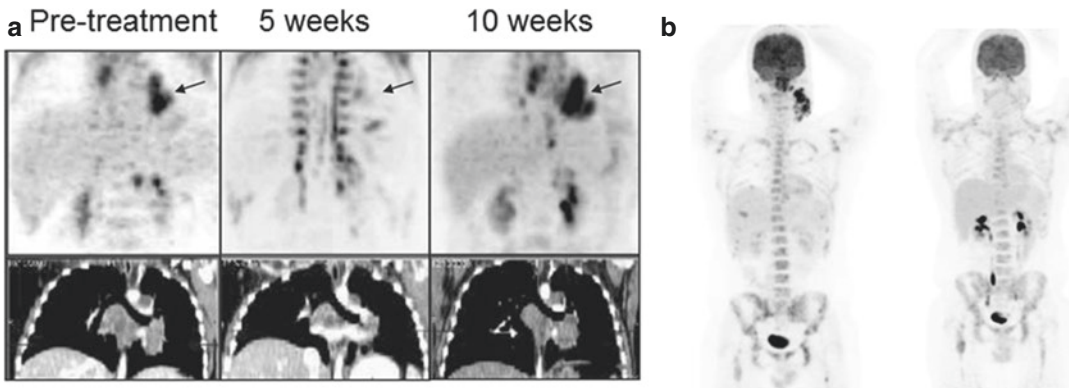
Response of NC patients to targeted inhibitors. (a) PET/CT of a 10-year-old patient to single agent HDAC inhibitor, vorinostat. Recurrence at 10 weeks was due to treatment interruption secondary to gastrointestinal toxicity. (Reproduced from Schwartz BE, Hofer MD, Lemieux ME, DE, Cameron MJ, West NH, Agoston ES, Reynoird N, Khochbin S, Ince TA, Christie A, Janeway KA, Vargas SO, Perez-Atayde AR, Aster JC, Sallan SE, Kung AL, Bradner JE, French CA. Differentiation of NUT midline carcinoma by epigenomic reprogramming. *Cancer Res* 2011;71(7):2686–96. <https://doi.org/10.1158/0008.5472>.
